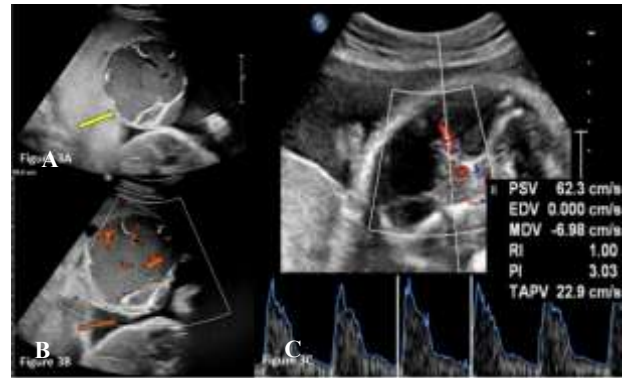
USG and Doppler imaging of case 4; (A) USG image showing a well-circumscribed mass lesion with internal septations and hypo- and hyper-echoic texture; (B) color Doppler image showing vasculature within the substance of the mass lesion, aiding in differentiation of chorioangioma from other lesions and (C) color Doppler image showing raised MCA-PSV indicating fetal anemia.
